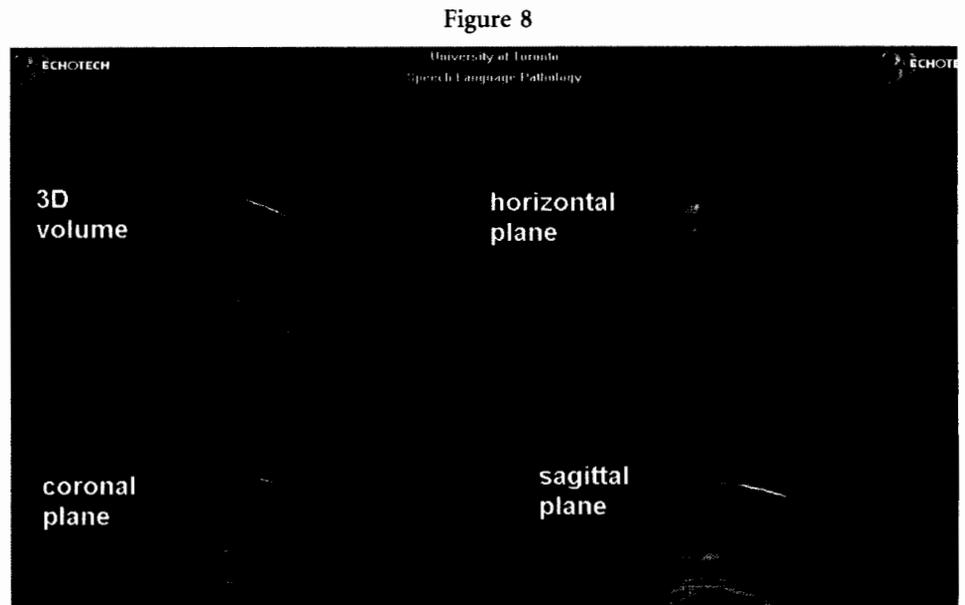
Orthogonal planes of a three-dimensional ultrasound volume of the sustained vowel /a/, spoken by a normal male adult participant.
